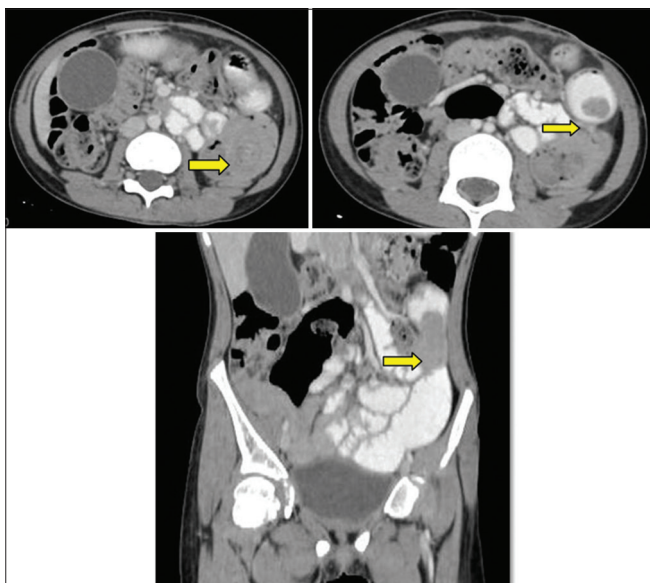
Multidetector computed tomography-enteroclysis in a 21-year-old patient showing jejunojejunal intussusception in the proximal jejunum. Axial and coronal images show a well-defined intraluminal soft-tissue dense polypoidal lesion noted in the mid-jejunum with a small bowel feces sign proximal to the lesion
